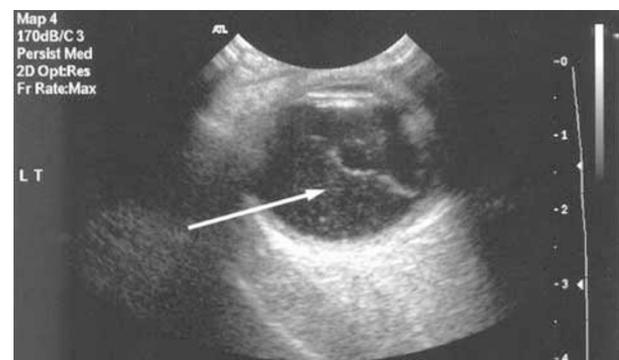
Ultrasound B scan showing subhyaloid collection of depomedrone (arrowhead).
